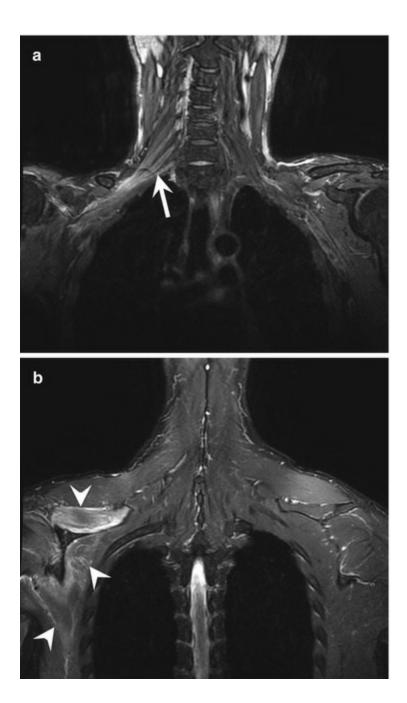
A 37-year-old patient with inflammatory polyneuropathy of unknown origin. (a, b) Coronal water-imaging with a three-point Dixon sequence MRI show an enlargement of the right cervical roots (*arrow*) and a muscle edema of the muscles of the right scapular girdle (*arrowheads*)
